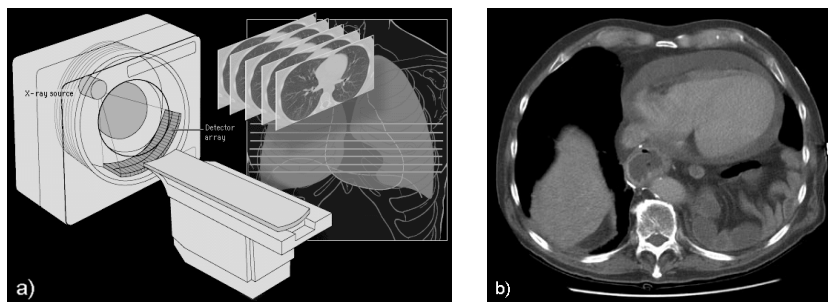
a) CT scanner device. b) Sectional CT image showing different organs.
